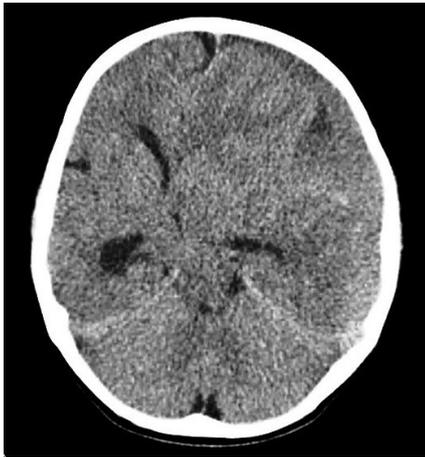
CT scan shows SDH in left frontotempoparietal region.
